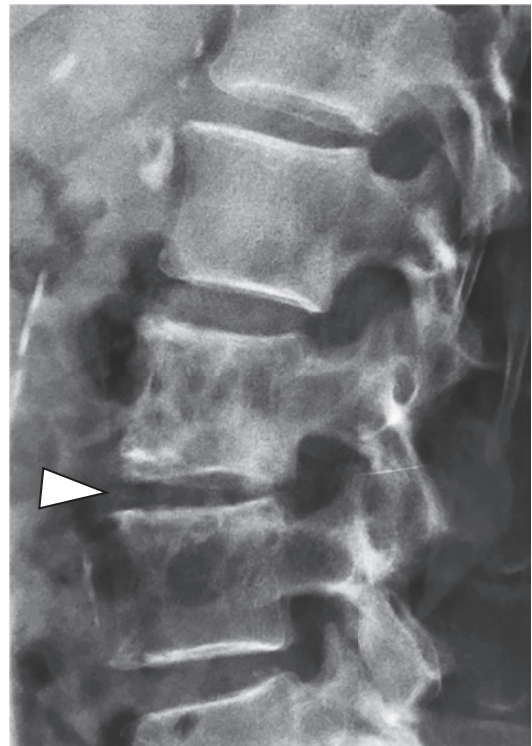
Spinal sarcoidosis. Lateral radiograph of the lumbar spine shows mild disc narrowing (arrowhead) and heterogeneous osteolytic-sclerotic appearance of the adjacent vertebrae
